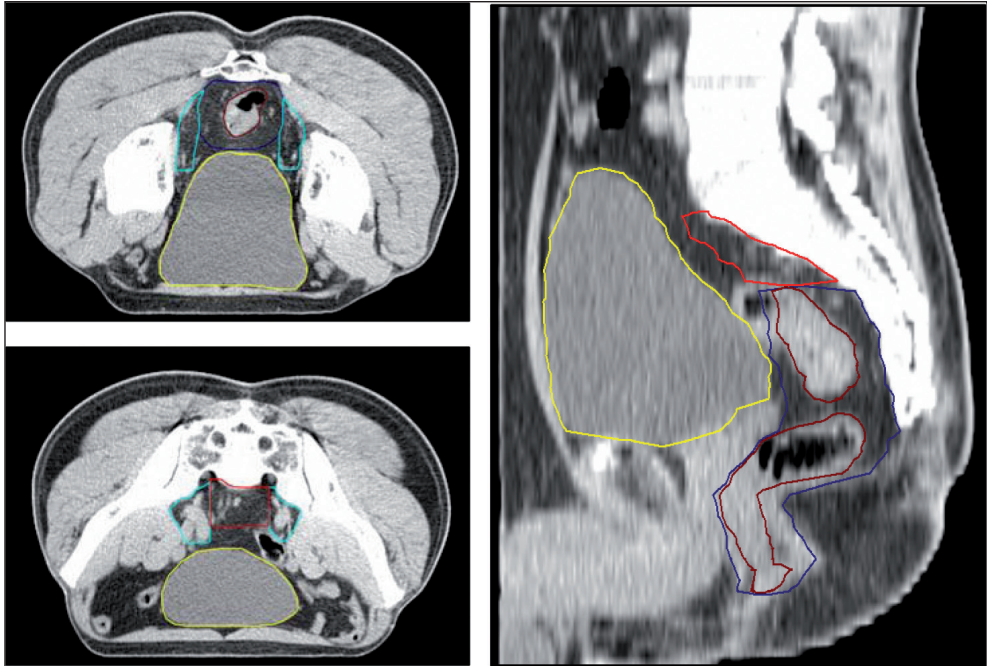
Example of the delineated structures on the planning CT of a male patient. On the left axial views at two different levels are shown, on the right a sagittal view. The delineated structures are the bladder, the rectum, the MesoRect including the sphincter complex, the presacral region and the lymph node regions left and right.
